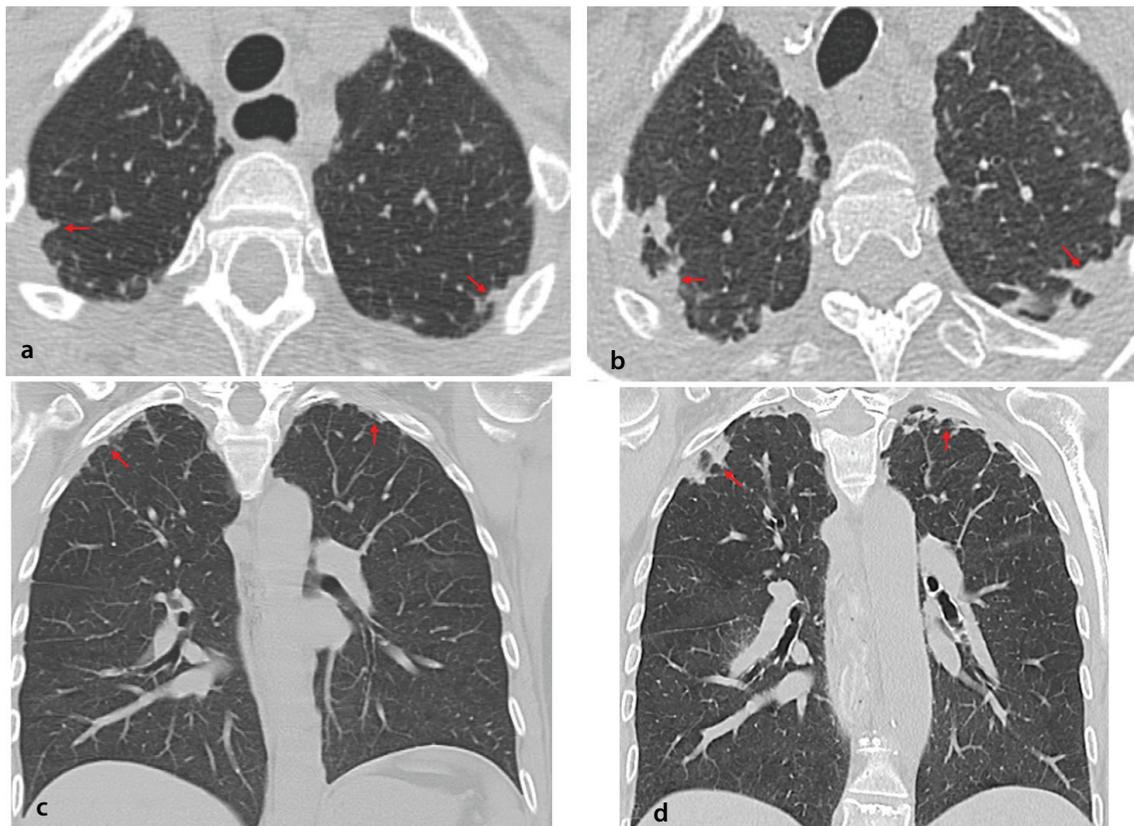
Pleuroparenchymal fibroelastosis pattern on high-resolution chest computed tomography (CT). Initial axial (a) and coronal (c) CT images demonstrate dense pleural and subpleural fibrosis with upper-lobe predominance. Follow-up CT images obtained one year later (b, d) show marked progression of fibrosis with associated volume loss and architectural distortion (arrows).
